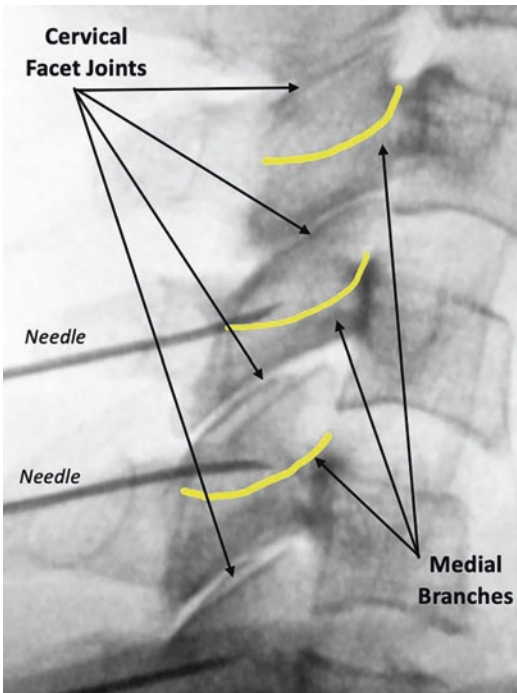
Lateral radiograph of cervical spine to show the articular pillars, demonstrating location to cervical medial branch nerves (yellow lines)
